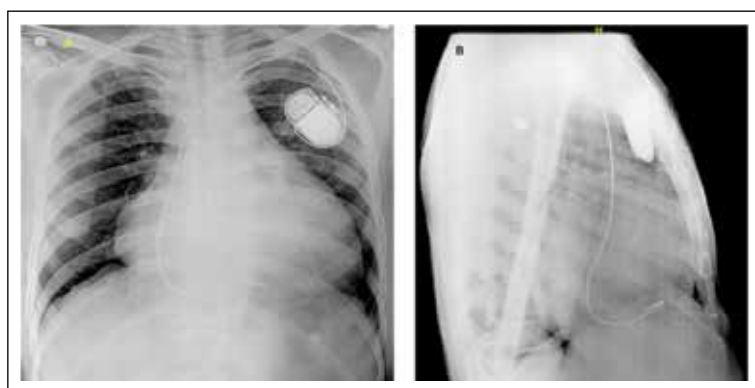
This is a case of right ventricular endomyocardial fibrosis (RVEMF) in view of AF with a slow ventricular rate who underwent endocardial VVI pacemaker insertion. RV basal septal / inflow septal pacing was done as the body and apex of the right ventricle were obliterated. Frontal (A) and lateral chest radiographs(B) show the lead positions.
